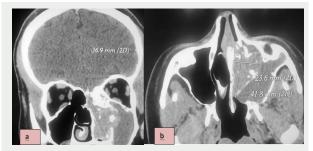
CT scan of the facial mass in the parenchymal window, coronal section (a) and axial section (b) showing a nasosinusal tumour formation with calcifications extending into the maxillary sinus and homolateral ethmoid cells in contact with the lamina papyricea and roof of the ethmoid.
